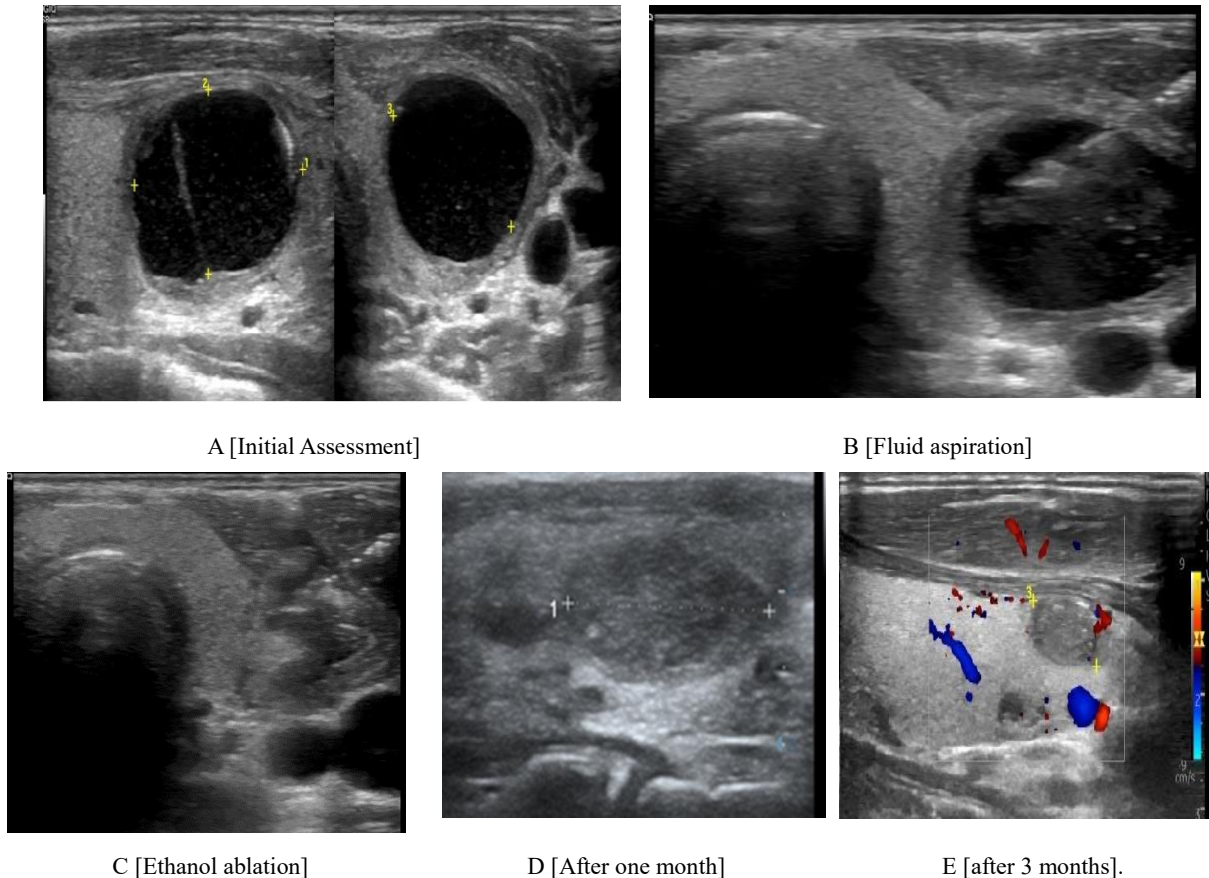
Ultrasound results of the first presented patient
